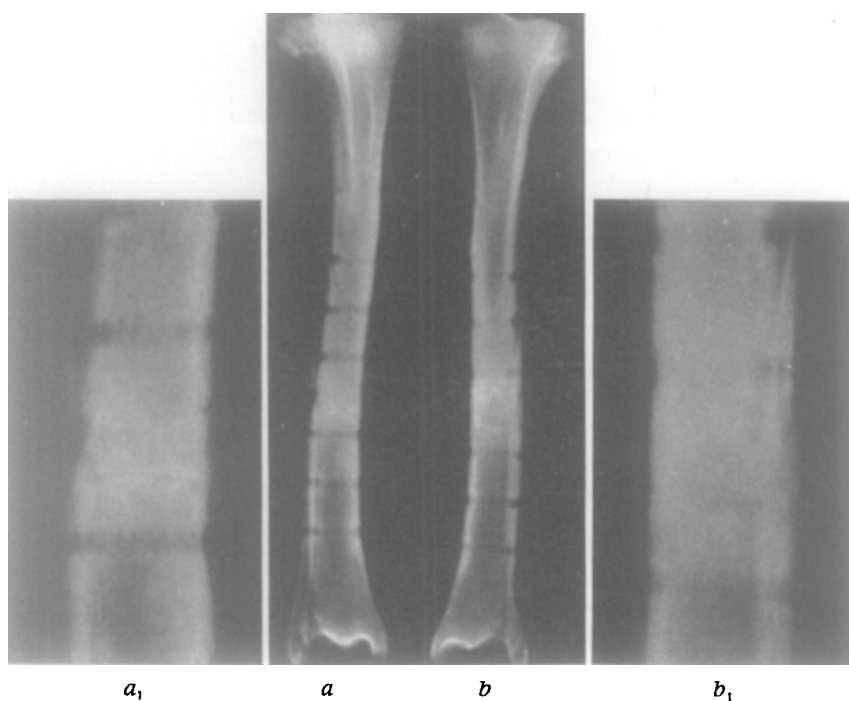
Roentgenograms showing the incorporation of the intermediate fragment after 7 (a) and 11 (b) weeks, respectively: a_1 - Partial enlargement after observation time of 7 weeks. The osteotomy gaps are almost completely filled; moderate endosteal callus. b_1 - Partial enlargement of roentgenogram at observation time of 11 weeks. The two osteotomy gaps are no longer visible. Decreased mineral content in the intermediate fragment as a sign of reconstruction in progress. A tendency to spongy transformation within the distal main fragment.
